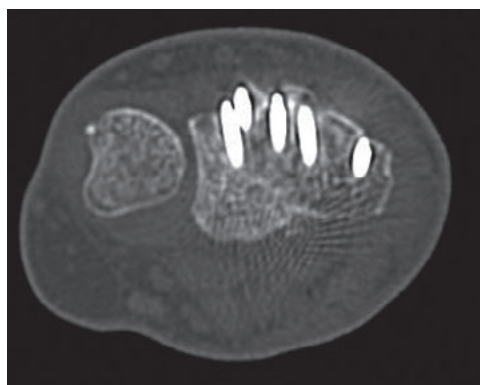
During the study period, one patient had an extensor pollicis longus (EPL) rupture, which may have been caused by either a protruding screw that was not identified on DTV, or fracture fragment spicule obscuring the obtained view as identified on computed tomography.
